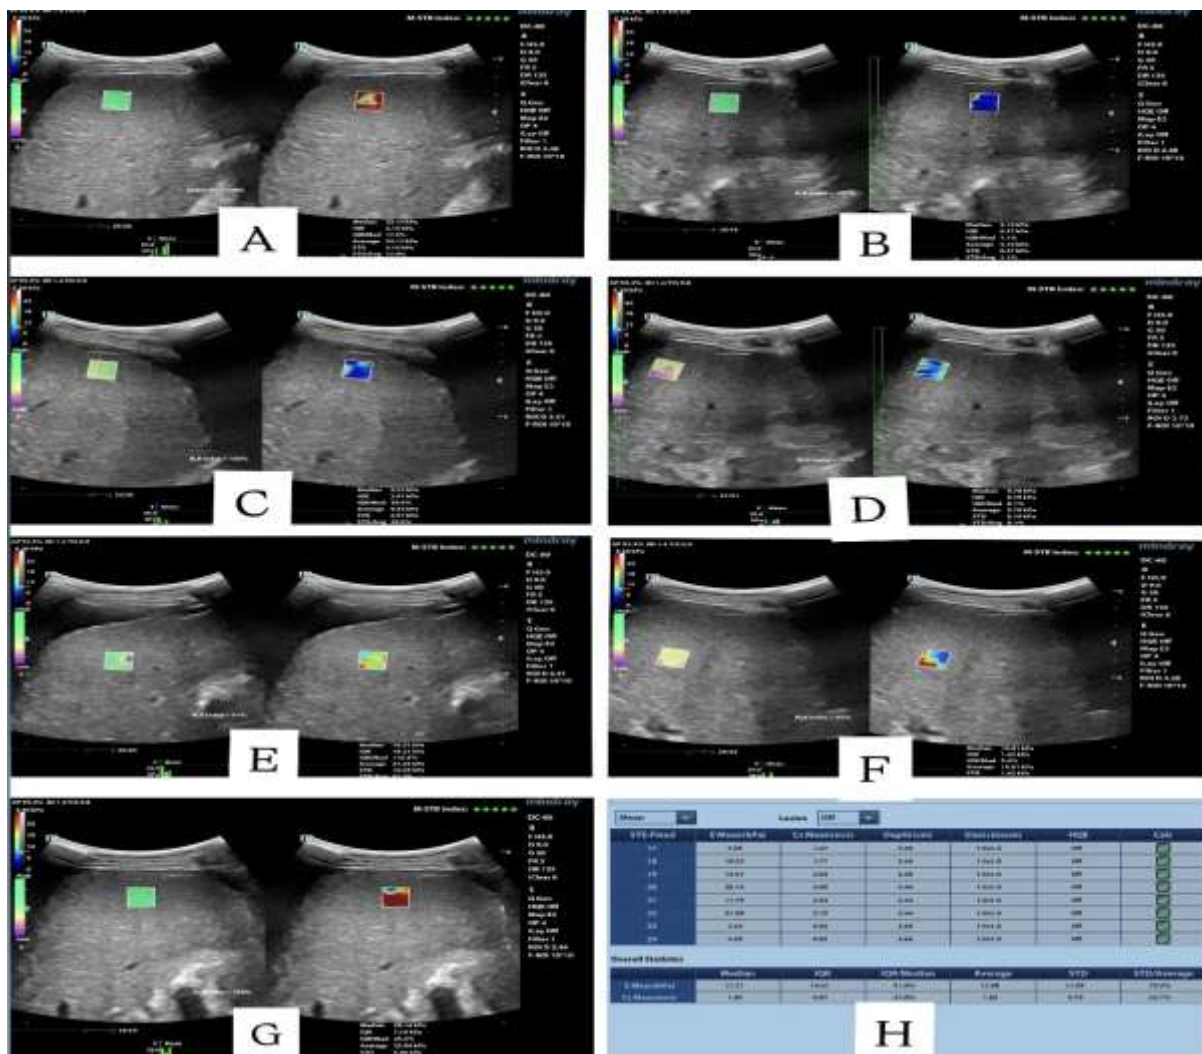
Liver SWE scans depicting the elastographic evaluation of liver fibrosis. A-G represent the gray scale images with color scale depiction of liver stiffness in kPa. H represents the statistical summary of the results obtained through the elastography technique, indicating the median, interquartile range, mean values, and measure of variability. Source: Original figures provided by the authors using MINDRAY DC-80 ultrasound machine with Sound Touch Elastography.
